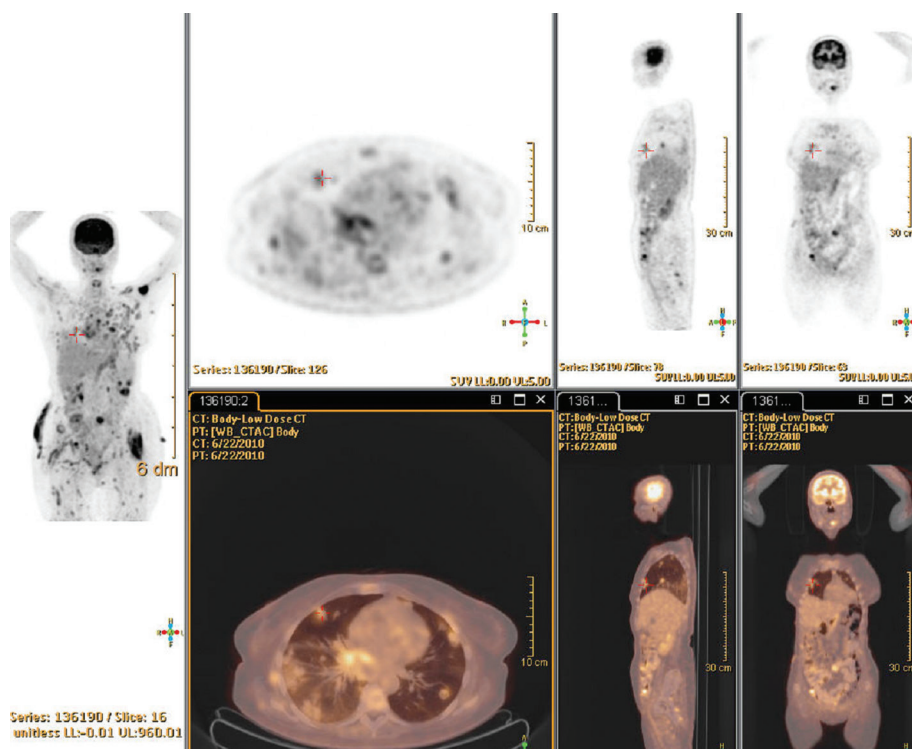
18F-FDG PET/CT whole-body scan displays multiple pulmonary, bone and soft tissue metastases and a disease progression
